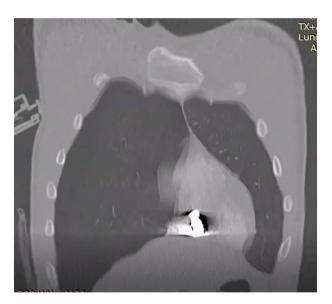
CT scan (coronal view) executed on the first postoperative day showing the location of the projectile.
